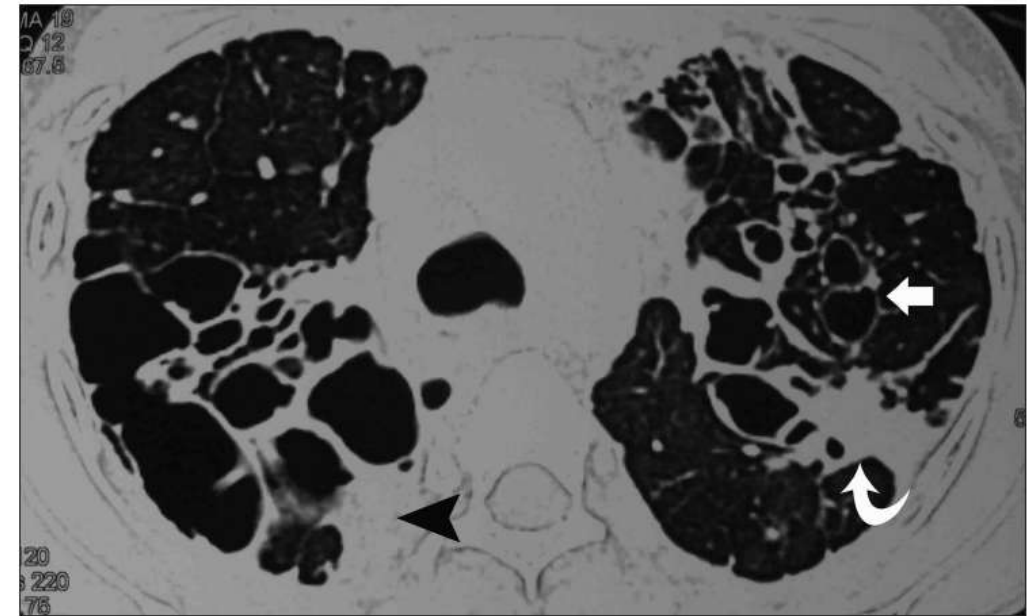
Axial HRCT (lung window) shows a mosaic pattern. There is central bronchiectasis with mucoid impaction in many of the bronchiectatic cavities (thin arrow). Also seen are centrilobular nodules in a tree-in-bud pattern (bold arrow)
